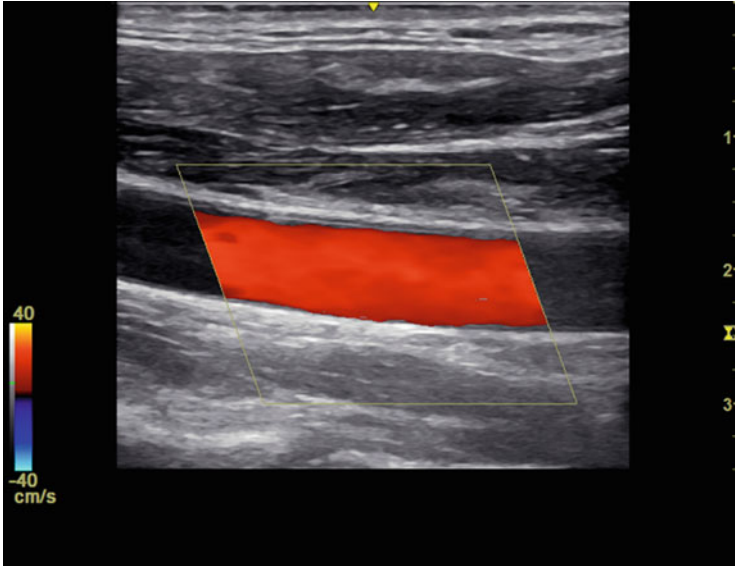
Color Doppler of a common carotid artery. Note that the portion of the lumen within the sample area (*yellow box*) is displayed as red. This indicates that blood is flowing toward the incident ultrasound beam
